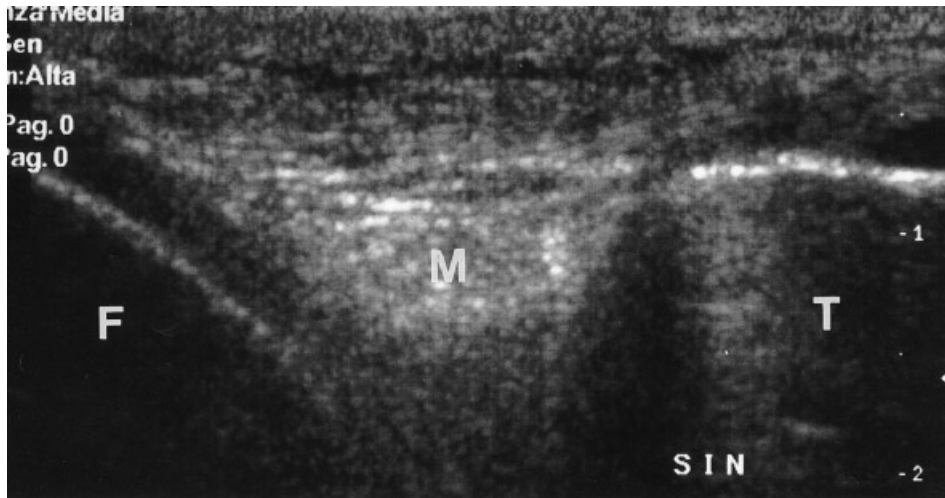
Normal medial meniscus in a 28-year-old man. Longitudinal sonogram shows the anterior horn of the meniscus (M), which appears as a homogeneous echogenic triangle without any internal hypoechoic or anechoic areas. F, medial femoral condyle; T, tibial plateau.
